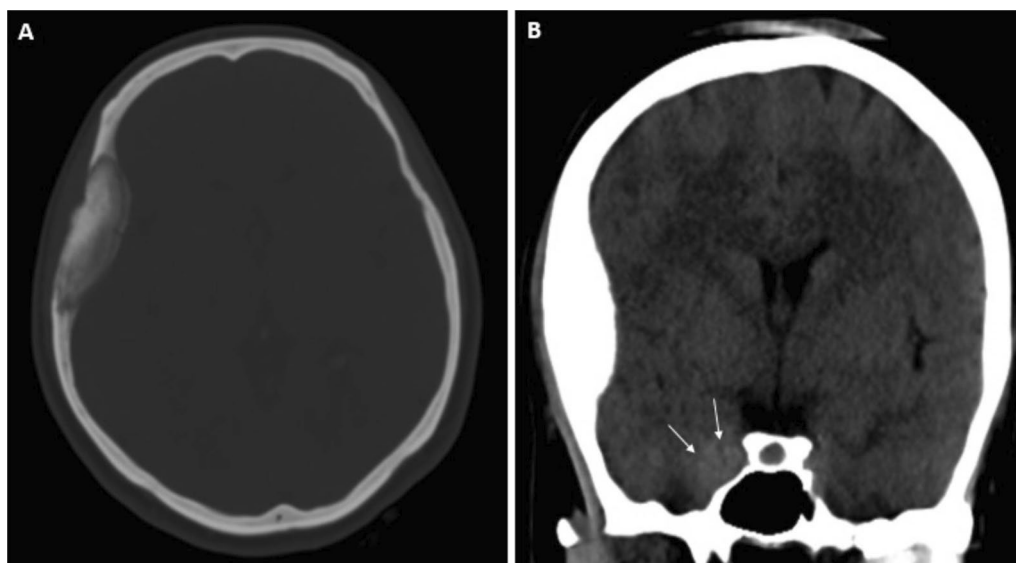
In the axial section (A) of brain CT without contrast, in the right frontotemporal region an appearance of expansile, monostotic fibrous dysplasia is observed in ground glass density. In the soft tissue window of the coronal section (B), fullness in the right cavernous sinus draws attention (white arrows)
